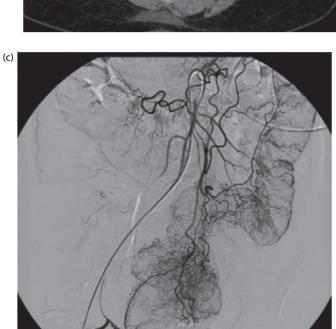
(a) A 70-year-old patient with upper gastrointestinal bleeding. A contrast-enhanced CT scan of the abdomen shows contrast extravasation from the jejunum (white arrow). (b) Coronal reconstruction of the same patient as in Figure 13.3a shows the bleeding to better advantage (white arrow). (c) Transcatheter mesenteric angiography shows no clear evidence of contrast leak. (d) Superselective angiography with a microcatheter in one of the jejunal branches. There is clear extravasation of contrast corresponding to the bleeding point on the CT scan (white arrow). (e) Angiogram following particle and coil embolization. There is no bleeding and the normal branches are preserved.
